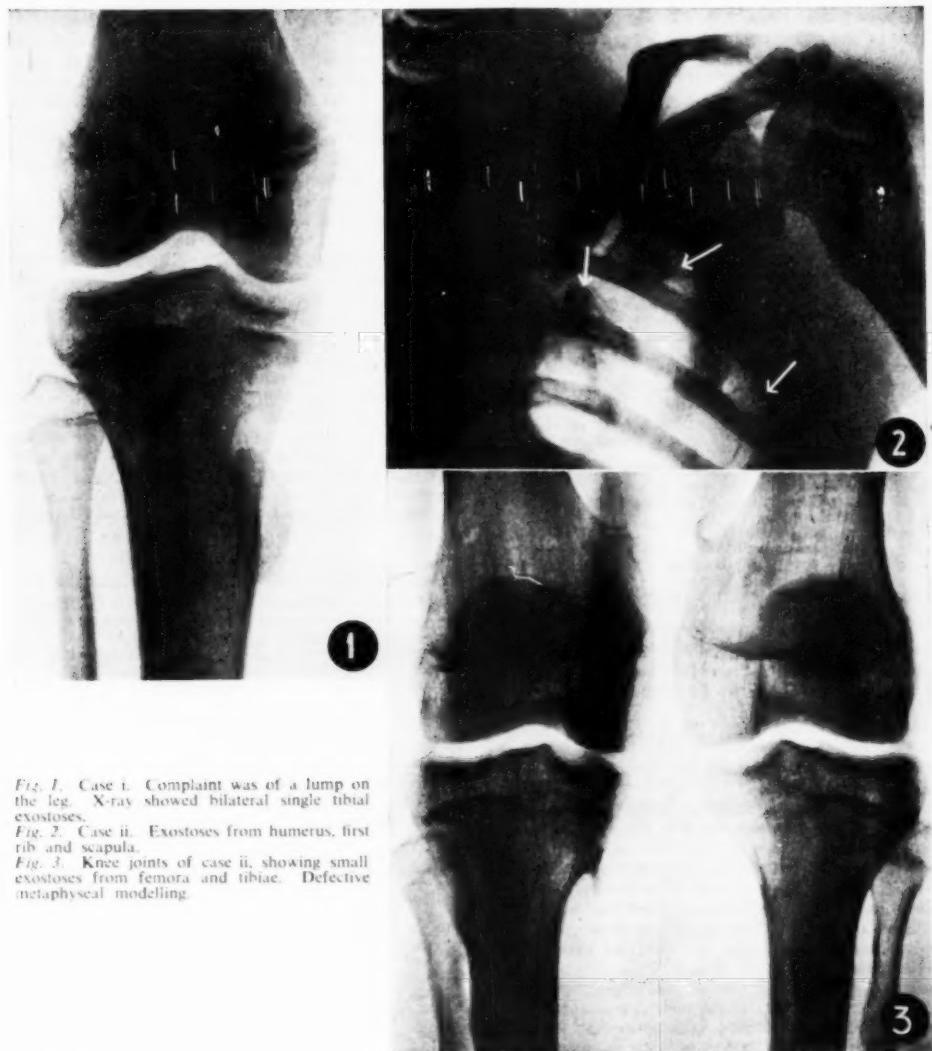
Case i. Complaint was of a lump on the leg. X-ray showed bilateral single tibial exostoses.
